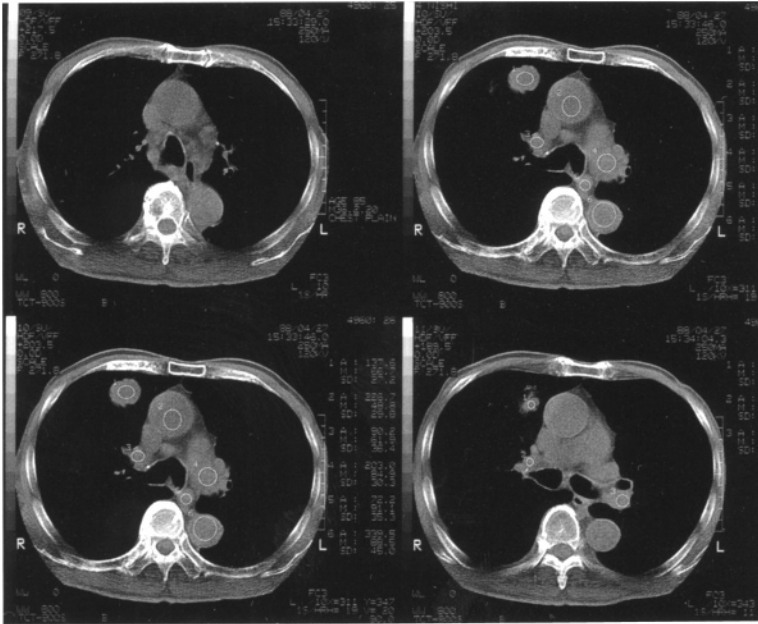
CT scans with mediastinal window setting shows a nodule of 2-cm in diameter in the periphery of right upper lobe
